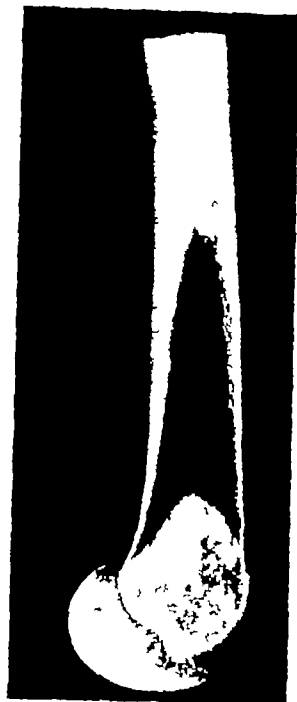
Roentgenogram of three sagittal sections of macerated femur, put together two adjacent ones representing two peripheral sections from medial condyle and a third of about 7 mm thickness corresponding to the center of the intracondylar area. Slices are arranged according to their natural position in the complete bone. Distal contour of Ludloff's spot is visible.
